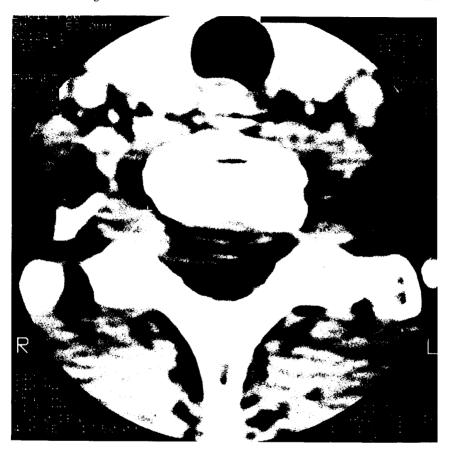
(Case 2) CT scan without contrast of C7 level of cervical spine showing bilateral masses in neural foramina.
